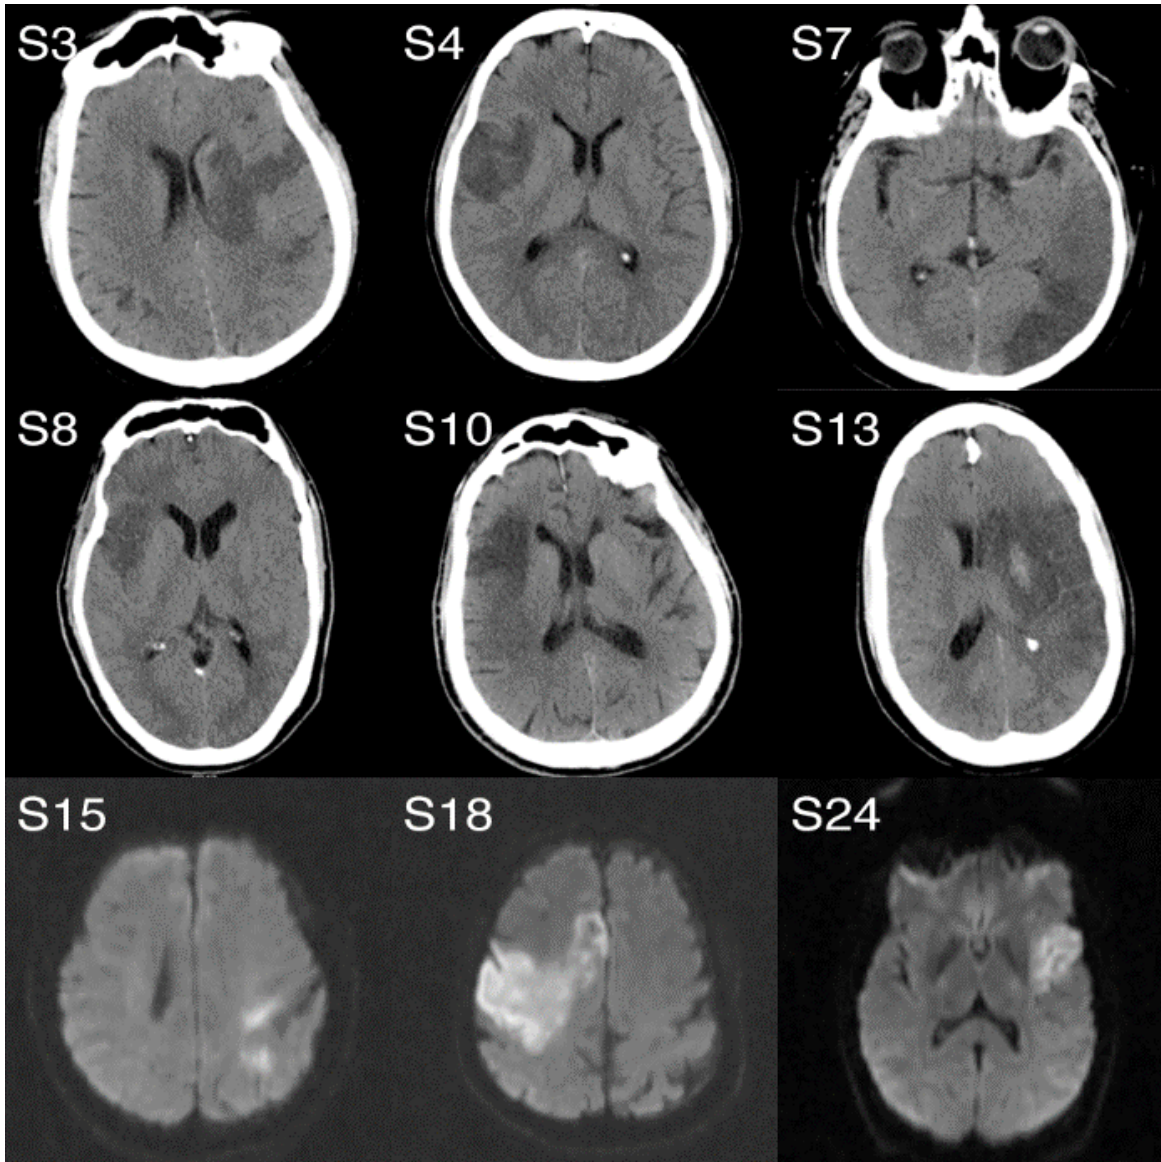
Representative images from the DWI MRI or CT taken at the closest time to EEG for the nine subjects with large (>4cc) infarcts indicate no important mass effect from the infarct onto the contralesional hemisphere, with the exception of S13.
